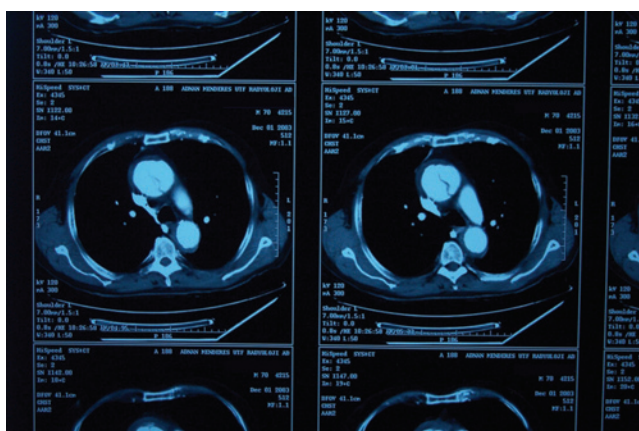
Progression of dissection and double lumen appearance was seen in computed tomography scan views.
